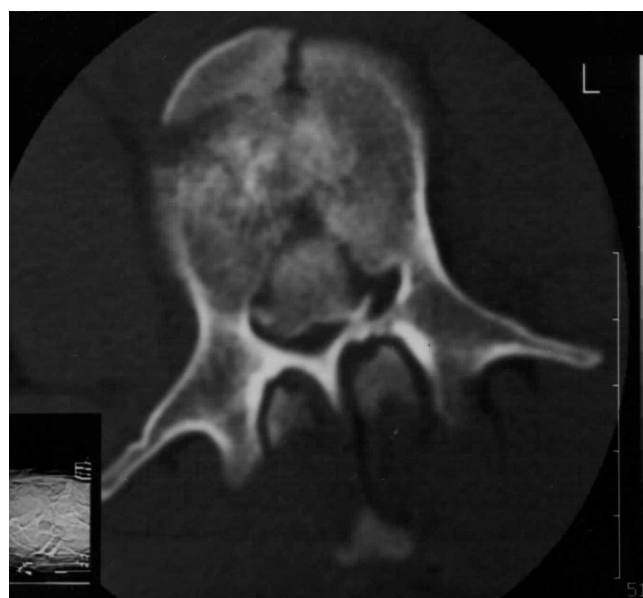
Axial CT image of a 23-year-old man with burst fracture of L2 vertebra. The patient was paraplegic due to the retropulsed bone fragments which severely narrowed the spinal canal.
